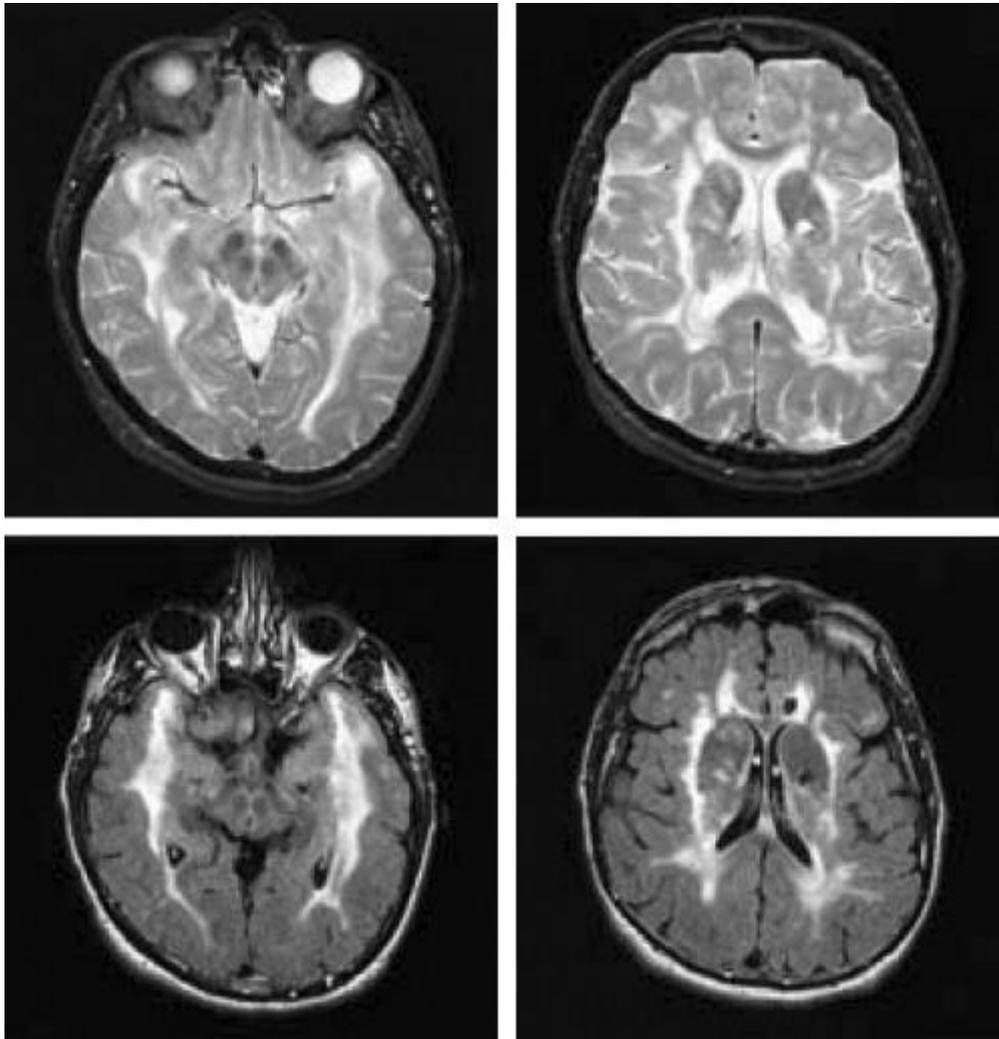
“MRI Brain Showing Small Vessel Ischemic Disease (SVID)”
